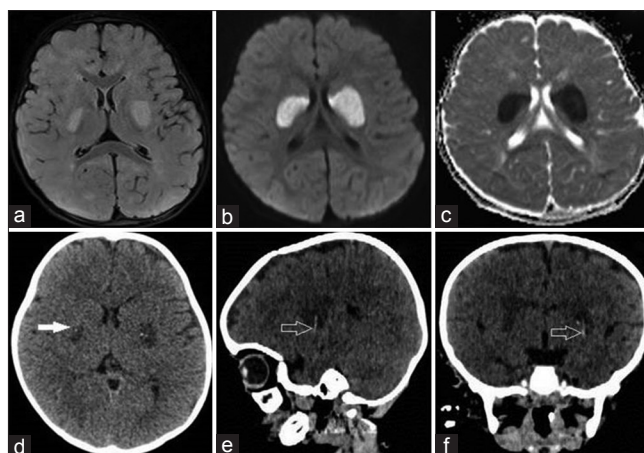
(a) Axial FLAIR MRI image of case 1 at the level of basal ganglia showing asymmetric hyperintensities in bilateral putamina (b and c) Diffusion weighted image showing diffusion restriction and reversal on ADC mapping suggesting acute infarct (d) Axial CT of the head showing asymmetric hypodensities in bilateral putamina with calcifications in the hypodensities (white arrow) (e and f) 3-D sagittal reconstruction and 3-D coronal reconstruction of the brain of case 1 showing calcified lenticulostriate arteries (hollow arrows)
